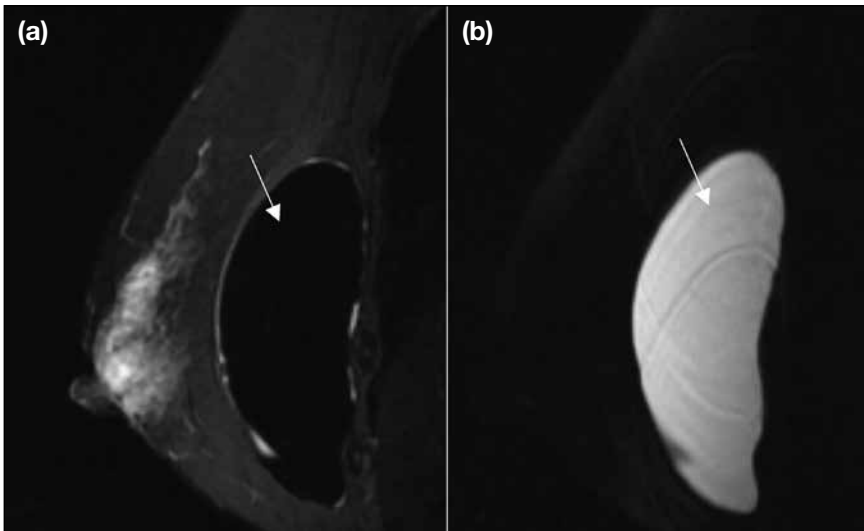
Subpectoral silicone breast implant with characteristic signals on specified magnetic resonance imaging sequences. (a) Silicone (arrow) is hypointense on the T2-weighted fat-suppressed, silicone-suppressed, saline-only sequence. (b) Silicone (arrow) is hyperintense on the T2-weighted short-tau inversion recovery silicone-only, water-saturated sequence. Note that this uncomplicated implant has a smooth border and is somewhat triangular in shape, with the vertical dimension more than twice the anteroposterior dimension.
